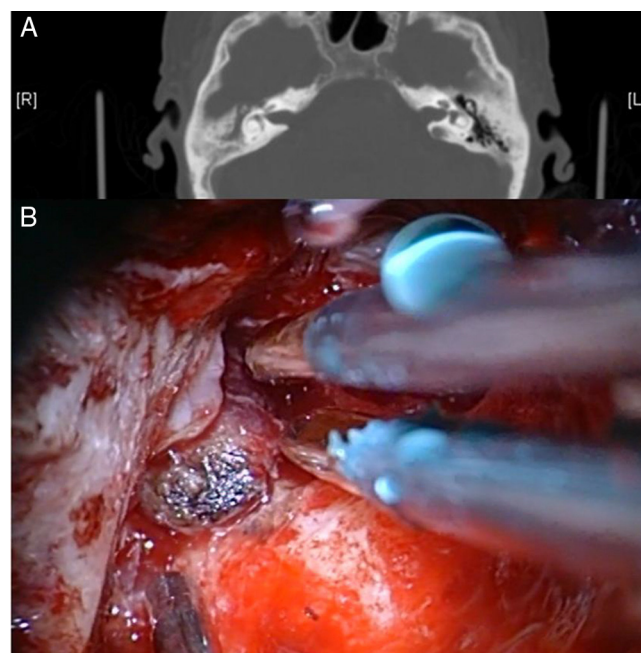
(A) CT axial cut showing the bone defect in the right ear. (B) Bipolar cauterization of the meningoencephalocele via transmastoid approach in the mastoid antrum and tympanic membrane.
